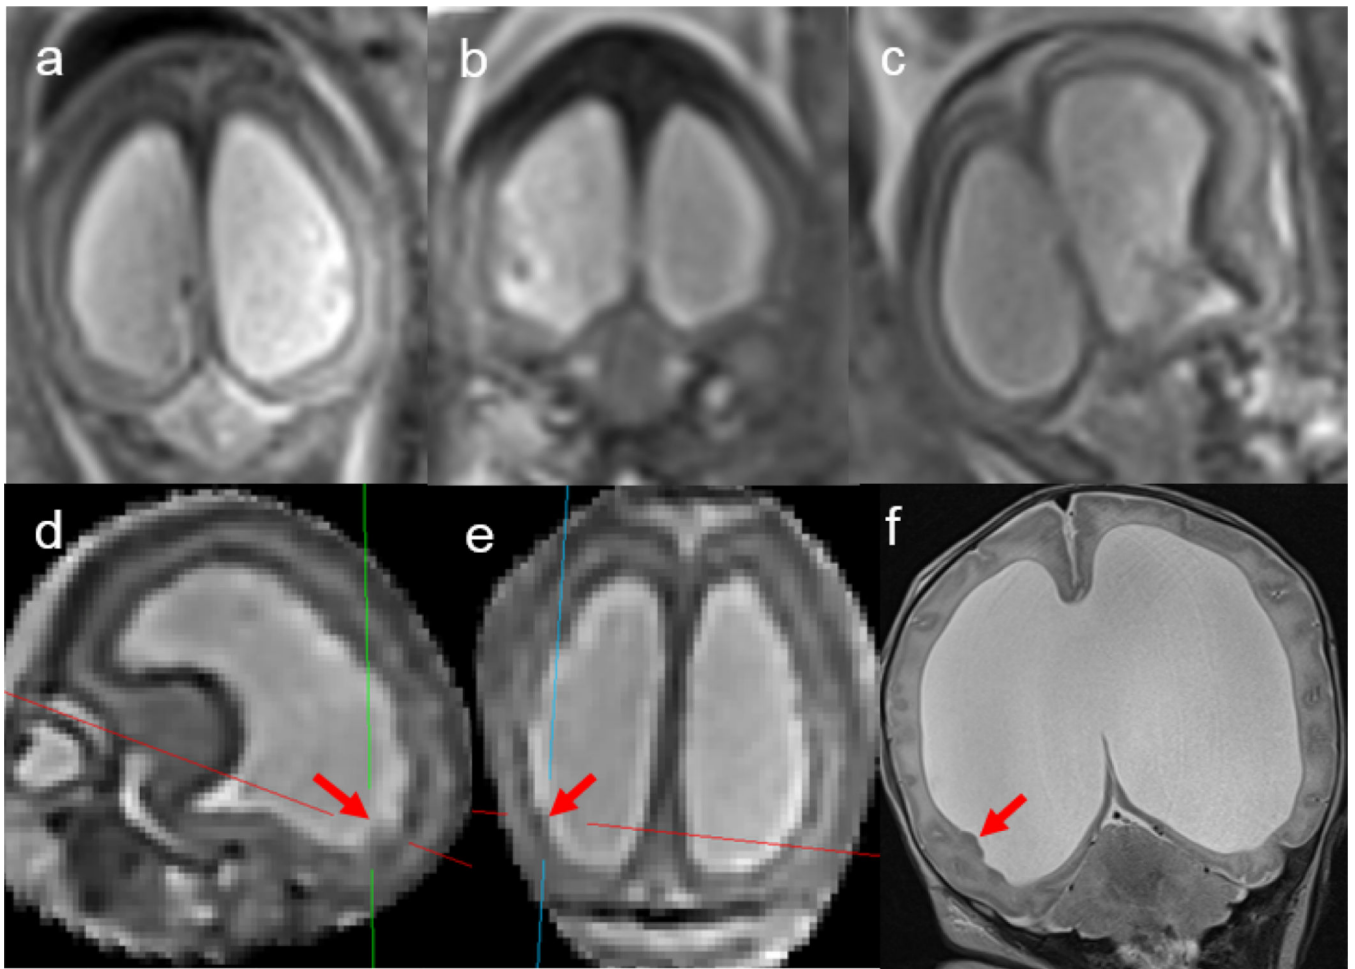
Coherent fetal volumes improve identification of subependymal gray matter heterotopia in a fetus with 22 weeks of gestation. (A, B, C) Coronal images from 3 different SS-FSE stacks. No heterotopias were prospectively identified by two experienced fetal neuroradiologists. (D, E) SVR reconstruction enables the detection of a focus of subependymal heterotopia (red arrows) due to the ability to cross-reference it in a coherent volume. (F) Postnatal T2-weighted image confirmed the focus of heterotopia (red arrow). Coherent fetal volumes have the potential to improve diagnostic accuracy.
